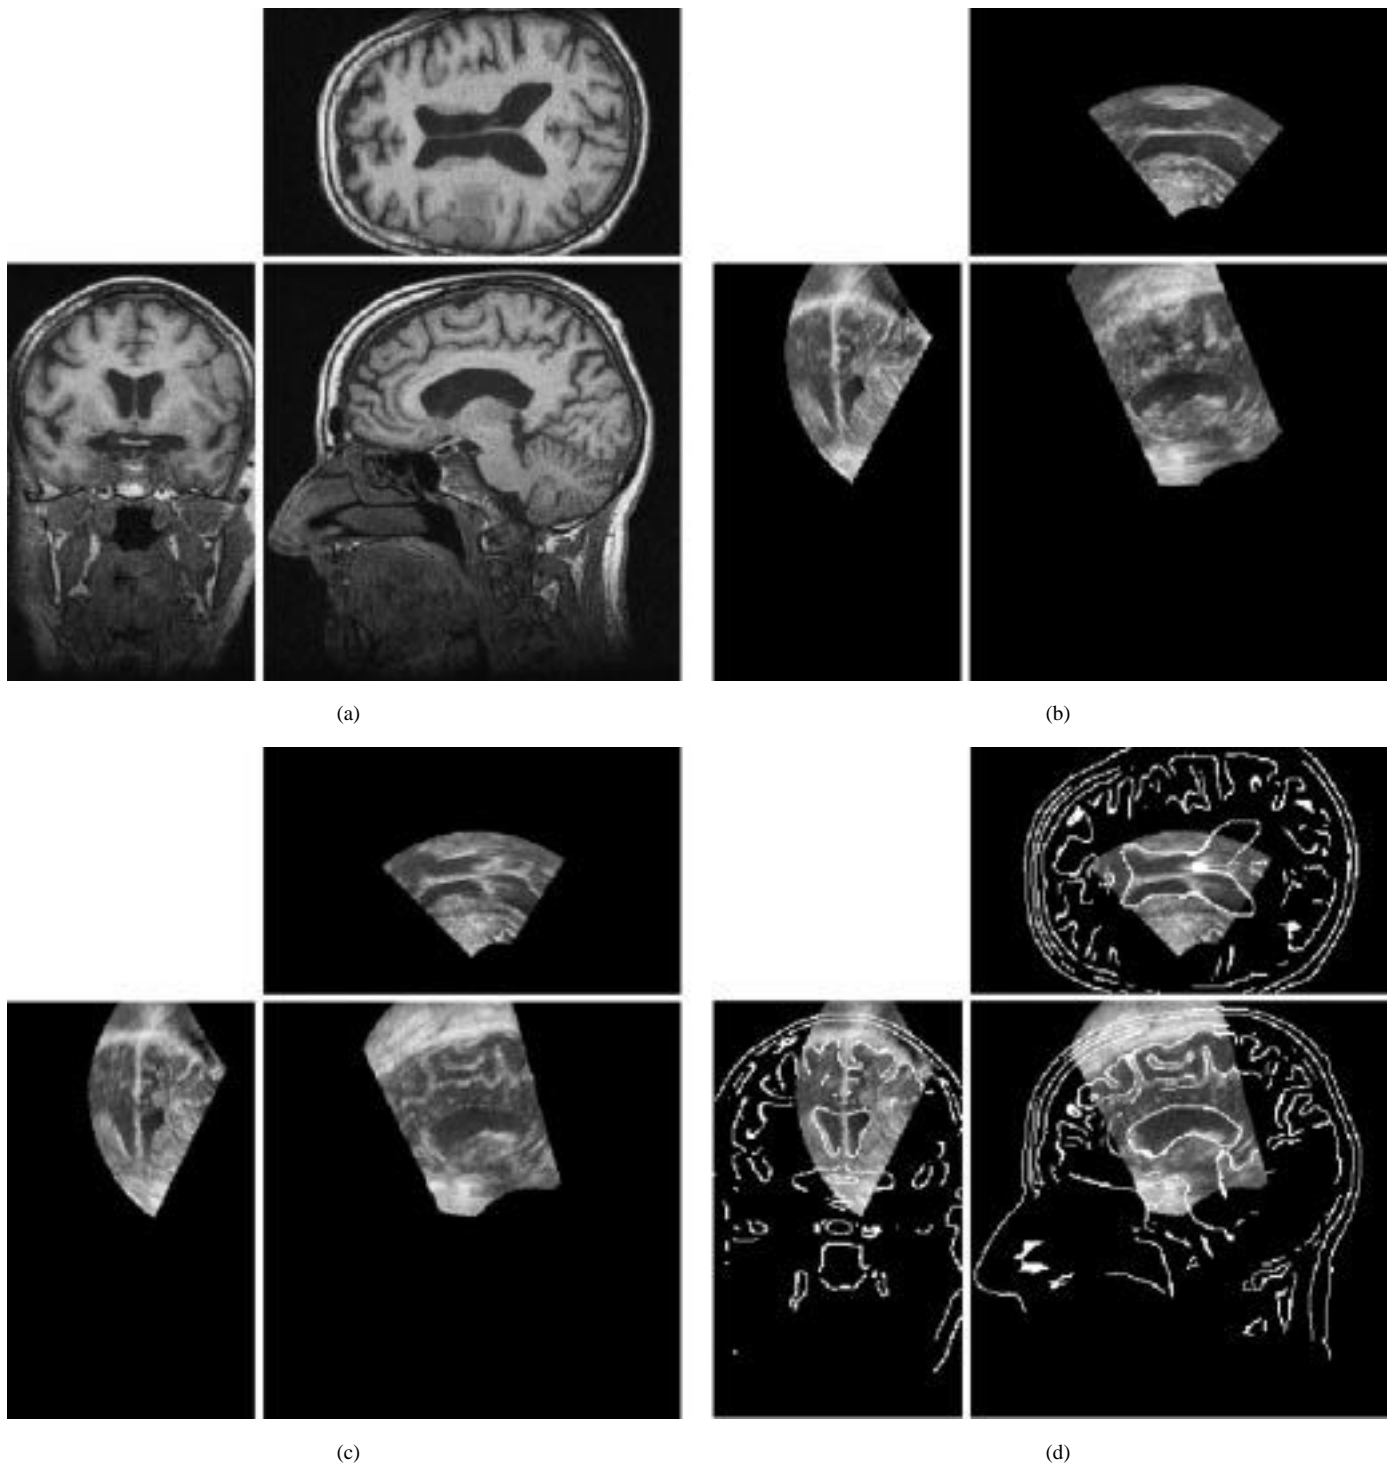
Example registration of the patient US/MR images. The US corresponds to the smallest acquisition cone among the dataset. This is the image we have found to be responsible for the largest registration error. (a) Preoperative MR (b) Intraoperative US (manually initialized) (c) Registered US volume (d) Registered US volume with MR contours overlaid.
